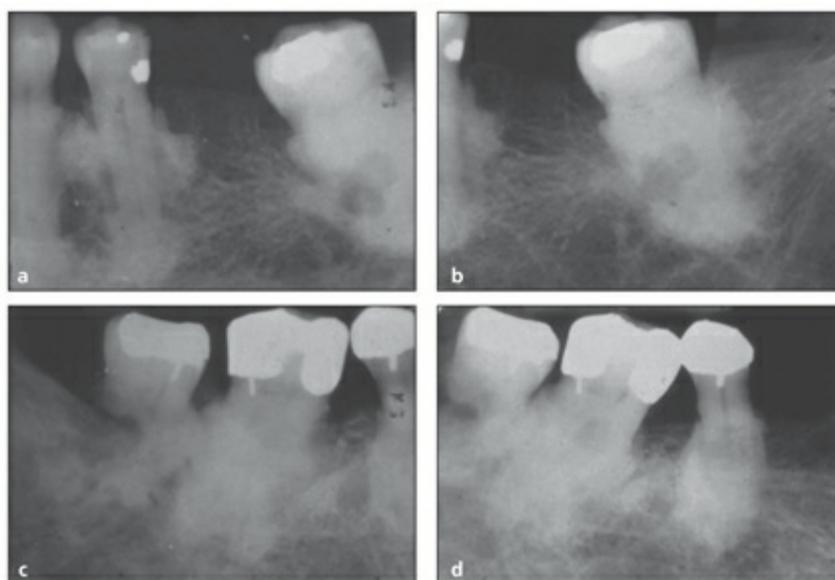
Characteristic intraoral radiographic features of Paget disease. Note the variable appearance of the canal space, periodontal ligament space, and lamina dura. (a) Areas of radiolucency. (b) Isolated sclerosis. (c) Isolated sclerosis and distal root resorption of the maxillary second molar. (d) Isolated sclerosis and hypercementosis of the second premolar. (Reprinted from Barnett and Effenbein¹³⁰ with permission.)
